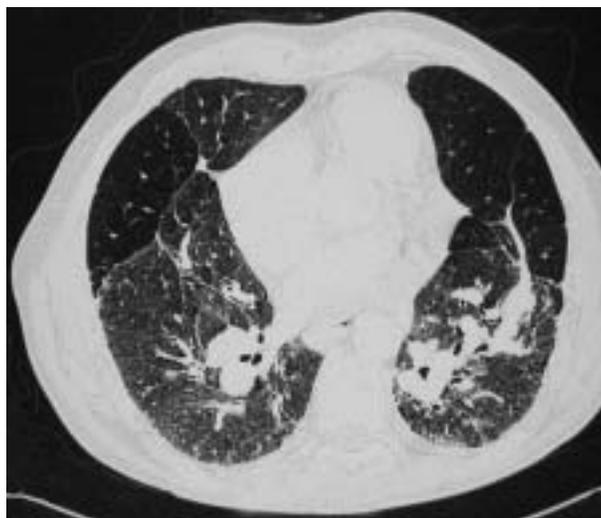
A 60-yr-old man with sarcoidosis. High-resolution computed tomography scan showing extensive confluent areas of linear fibrosis and dilated pulmonary arteries consistent with pulmonary hypertension.
